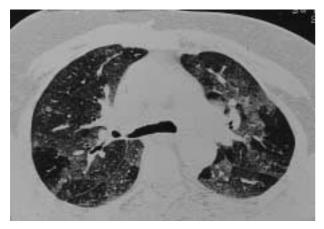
Computed tomography is more sensitive than the chest radiograph in detecting the changes of hypersensitivity pneumonitis. A characteristic pattern is of ground-glass shadowing with areas of decreased attenuation and air trapping on expiratory scans.
